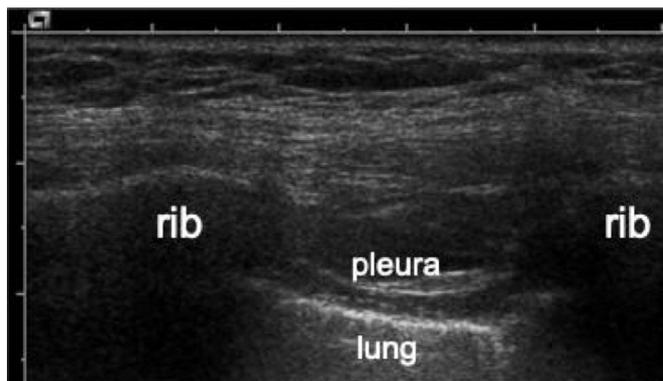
Another view of an ultrasound-guided intercostal nerve block anatomy.
